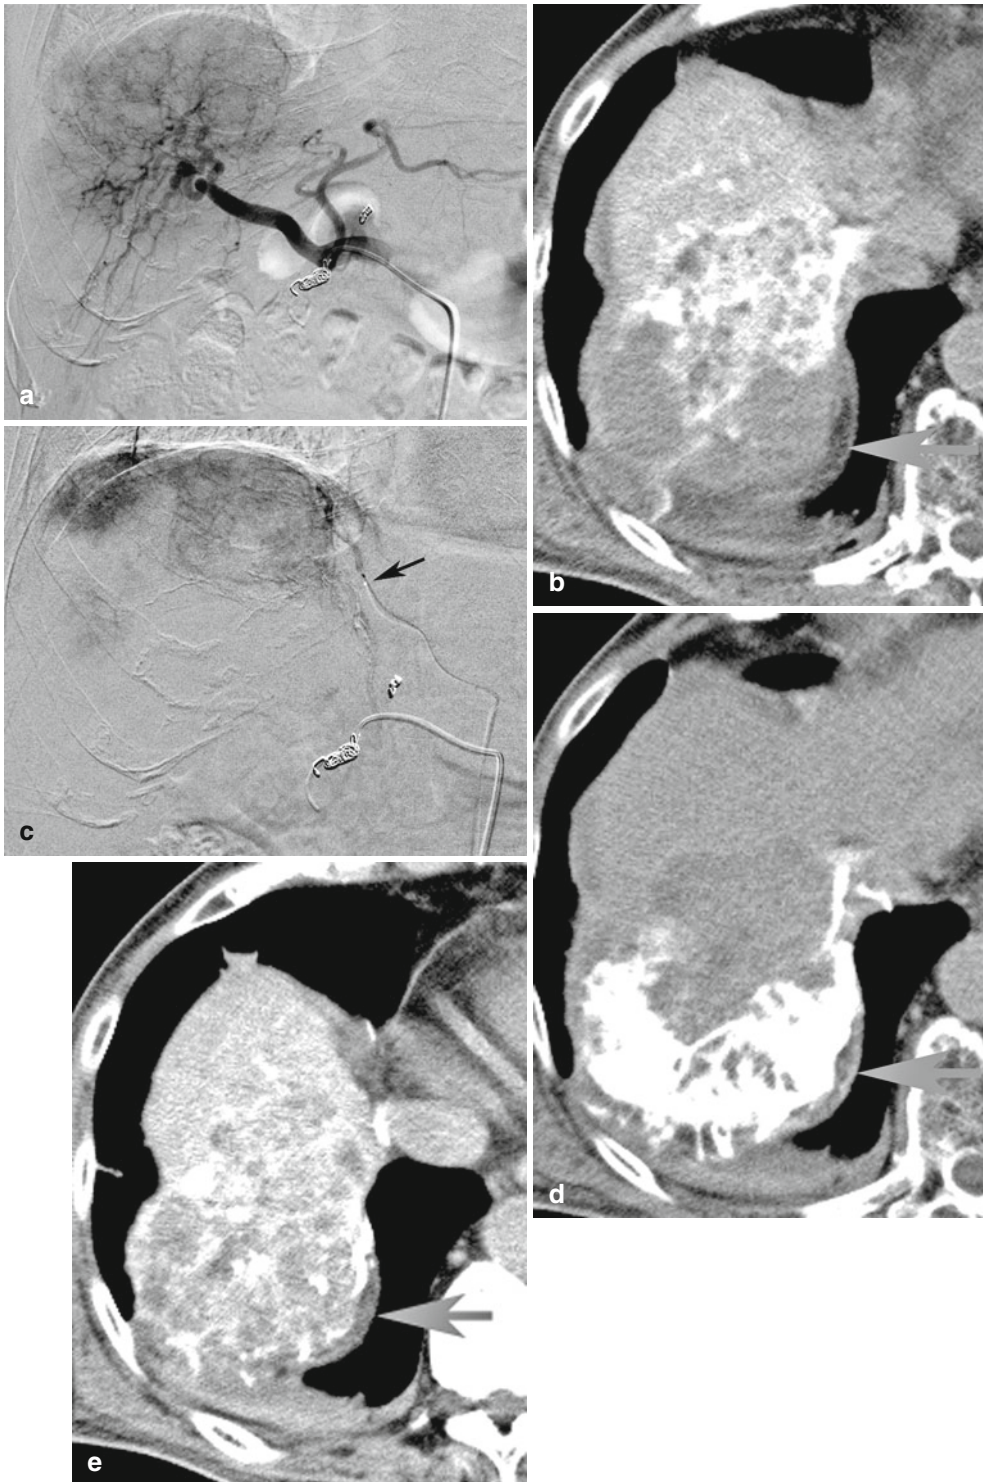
Management and reintervention for hepatic arterial infusion chemotherapy. (a) Angiography from implanted catheter-port system for HCC with portal venous thrombus. (b) CTA from the port shows an unenhanced area in segment VII. (c) Angiography from the right inferior phrenic artery
